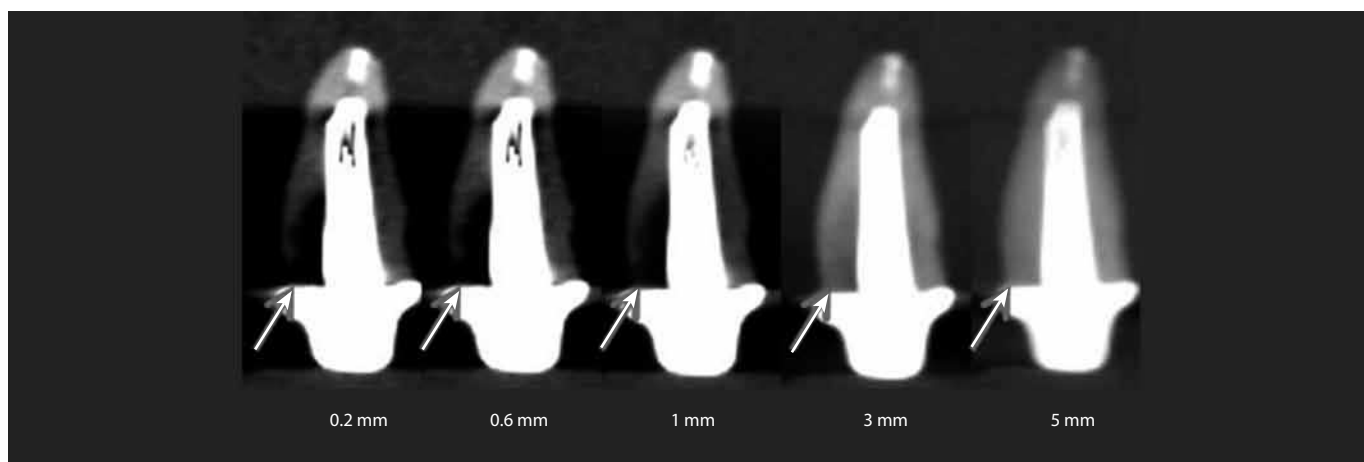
CBCT images of root canal filling with Pre-fabricated Post – Metal Screws in different slice thickness (0.2 mm, 0.6 mm, 1 mm, 3 mm and 5 mm) and planes (sagittal, axial and coronal).
